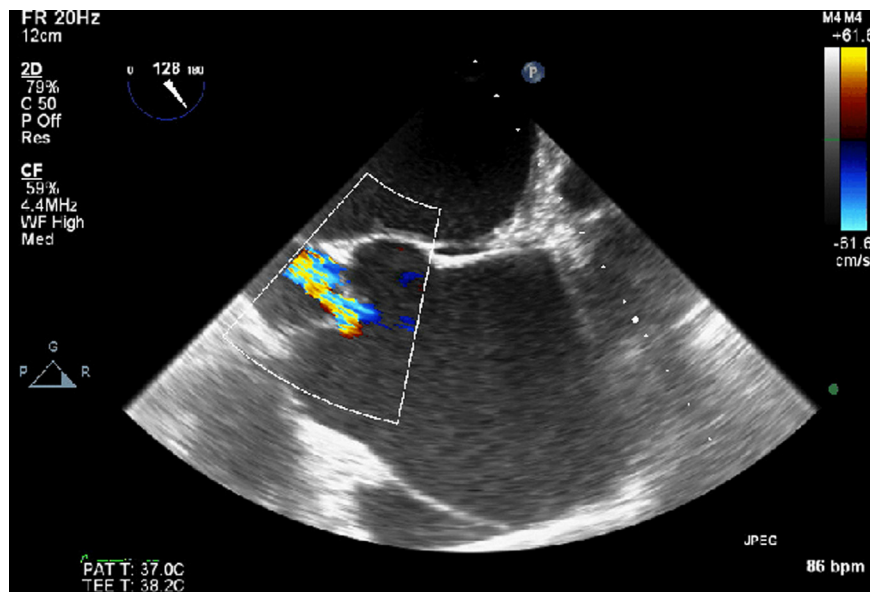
Midesophageal aortic valve long-axis image with color Doppler blood flow mapping showing large ascending thoracic aortic aneurysm, profoundly effaced sinotubular junction, and moderate aortic insufficiency. (Color version of figure is available online.)
